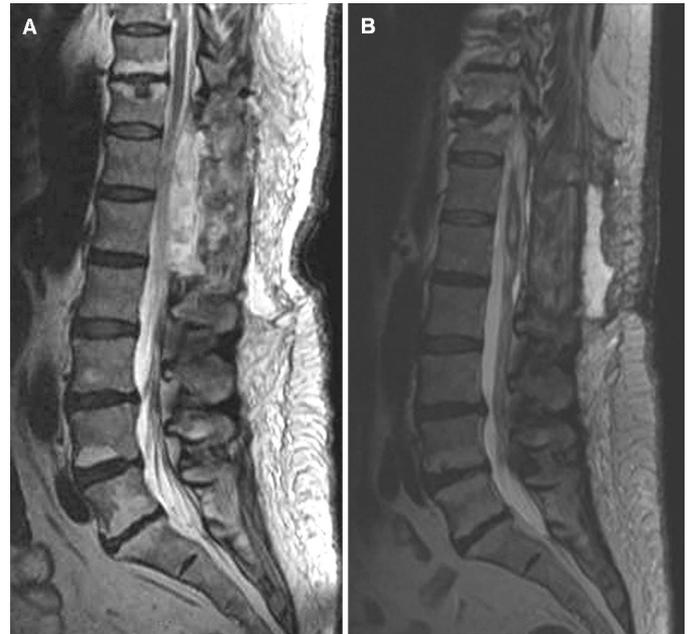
Postoperative T2-weighted sagittal images obtained immediately (A) and 1 month (B) after surgery showing successful bony decompression and collapse of the cyst. The conus resumed its normal midline location within the spinal canal. A small amount of cystic fluid reaccumulation is seen at 1 month.
